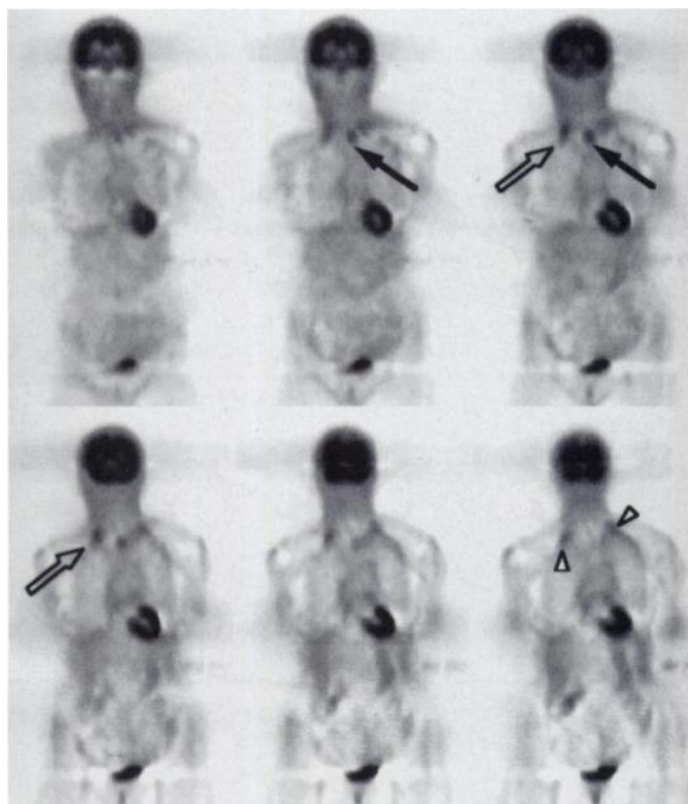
False-positive PET scan due to muscle uptake. PET scan shows bilaterally increased uptake of upper thoracic region. Chest CT scan was negative. The patient was clinically free of disease. Because of the location, bilaterality and the shape of uptake, this was concluded to be the uptake in the serratus anterior muscle.
